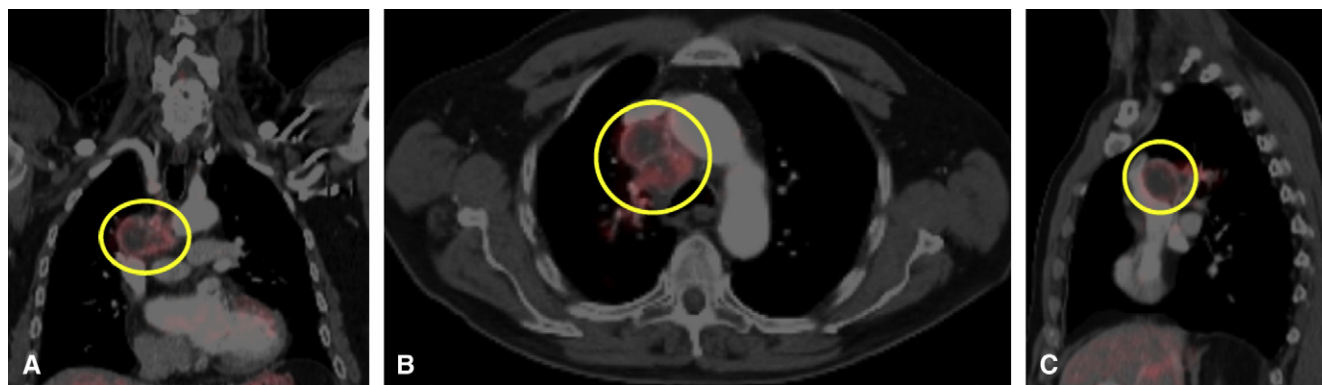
Fusion positron emission tomography/computed tomography scan of an isolated RCC metastasis to station 4R (per American Thoracic Society) MLN (circled): coronal (A), axial (B), and sagittal (C) views. RCC, Renal cell carcinoma; MLN, mediastinal lymph node.
